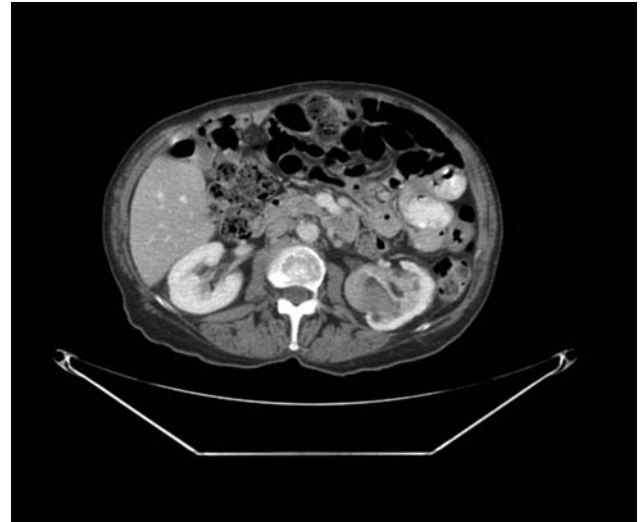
CT scan with the left renal mass.
